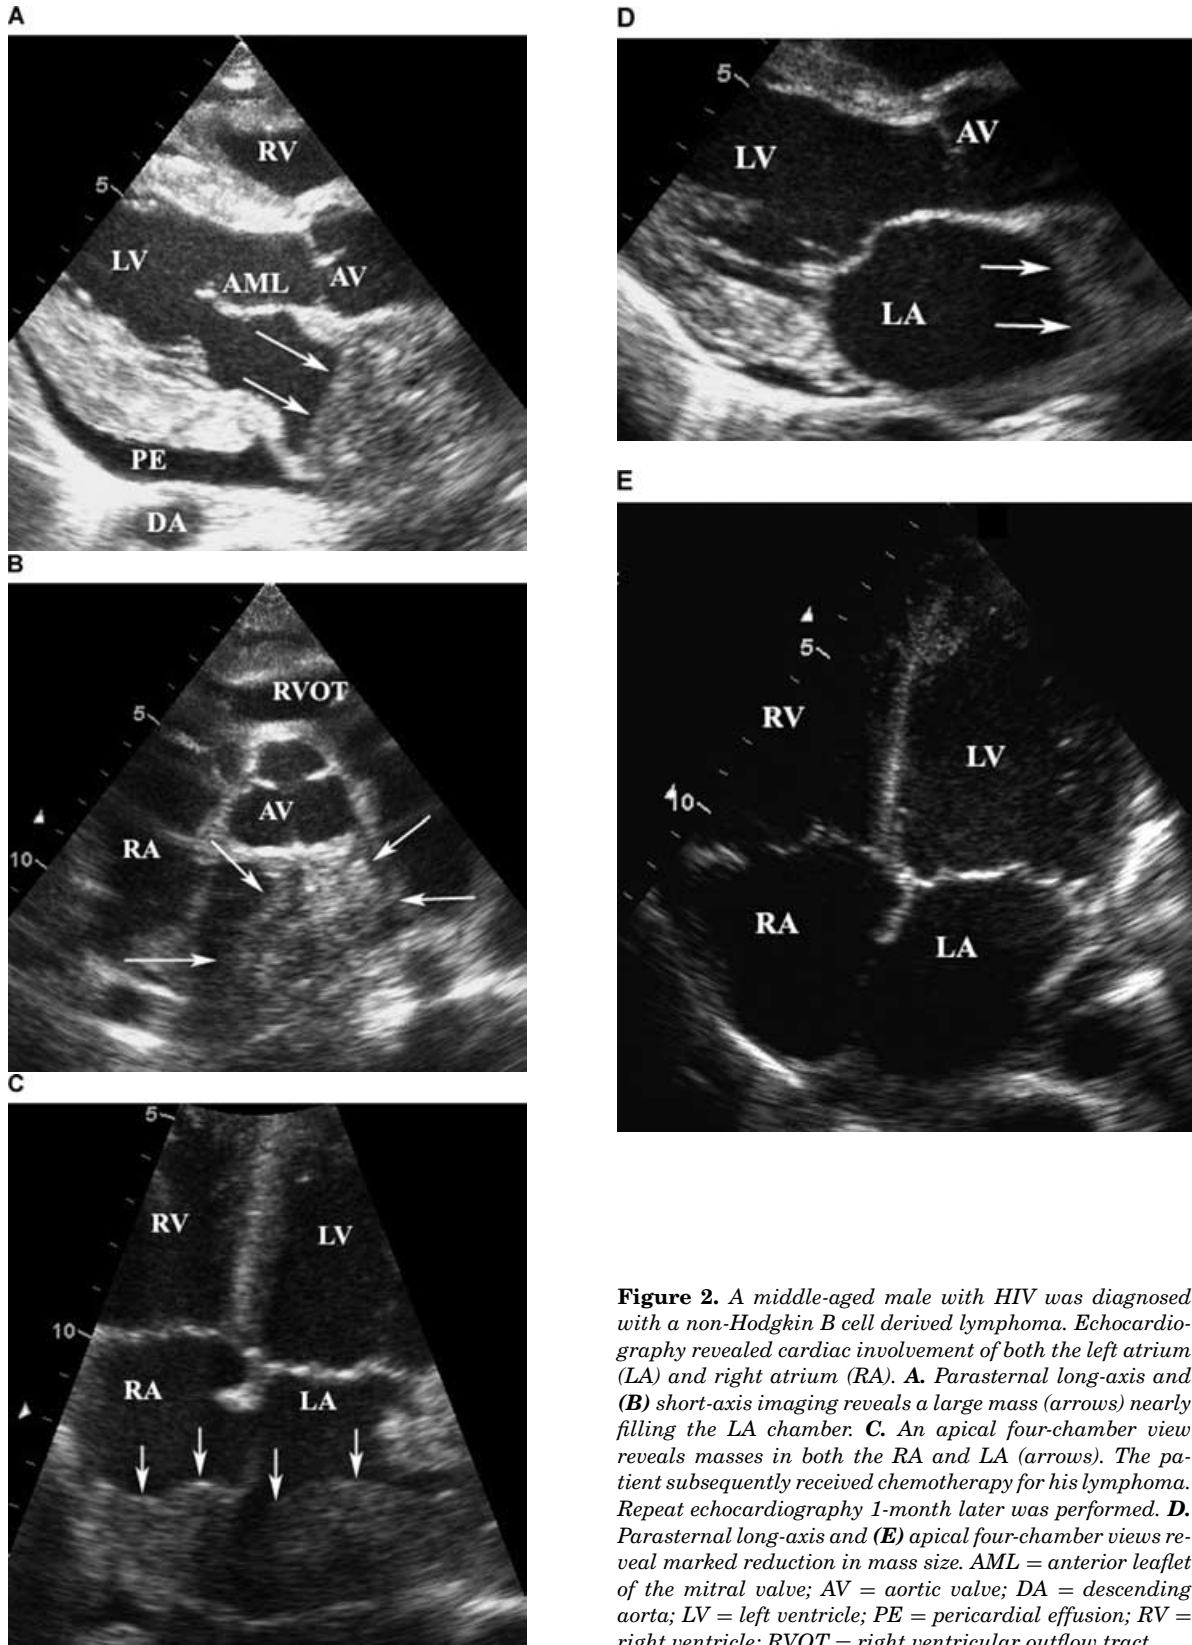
A middle-aged male with HIV was diagnosed with a non-Hodgkin B cell derived lymphoma. Echocardiography revealed cardiac involvement of both the left atrium (LA) and right atrium (RA). A. Parasternal long-axis and (B) short-axis imaging reveals a large mass (arrows) nearly filling the LA chamber. C. An apical four-chamber view reveals masses in both the RA and LA (arrows). The patient subsequently received chemotherapy for his lymphoma. Repeat echocardiography 1-month later was performed. D. Parasternal long-axis and (E) apical four-chamber views reveal marked reduction in mass size. AML = anterior leaflet of the mitral valve; AV = aortic valve; DA = descending aorta; LV = left ventricle; PE = pericardial effusion; RV = right ventricle; RVOT = right ventricular outflow tract.
